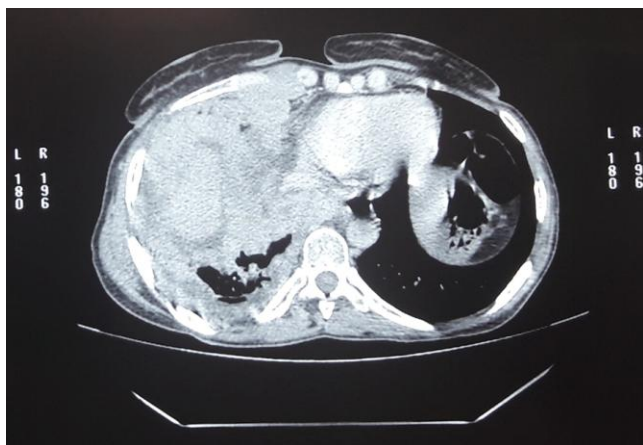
CT scan of the chest showing right tumoral process
